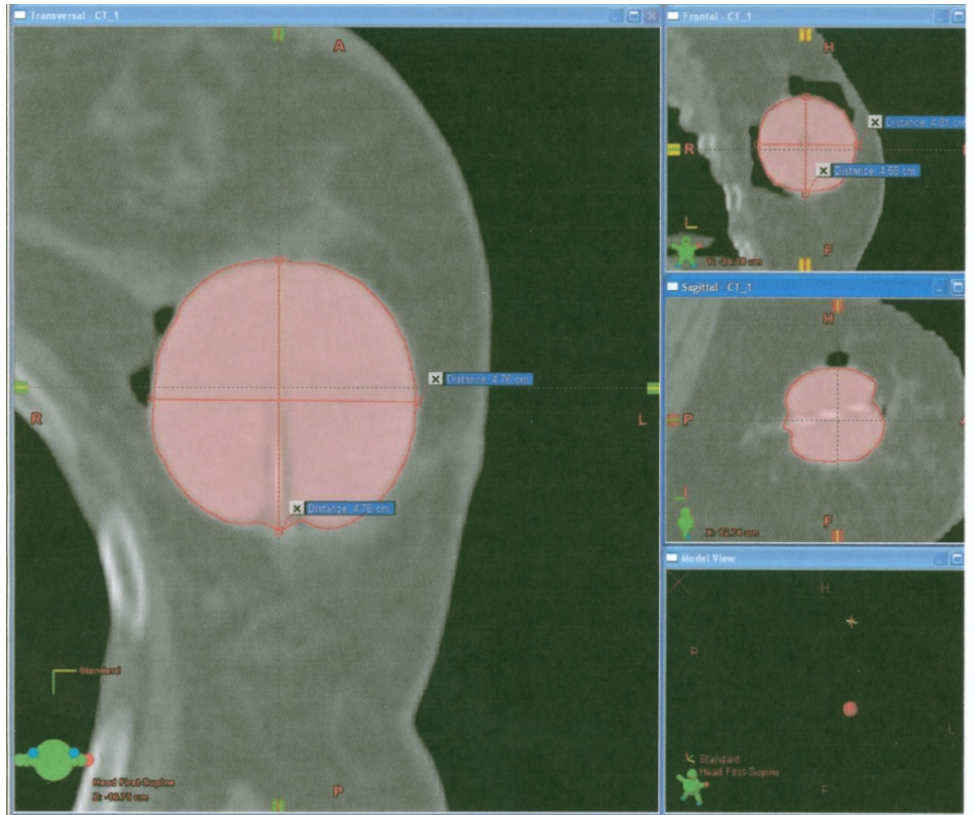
This figure shows the measured diameters in three different orientations. Shown are the central CT slices with the longest diameters. In this figure, the diameters in all the CT views and directions are between 4.0 cm and 5.0 cm and therefore meets the requirements for the 4.0 - 5.0 cm diameter fluid inflated balloon.
